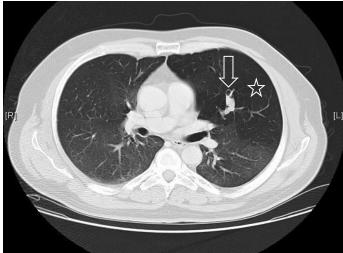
The previous left mid zone nodule is revealed as mucous impaction on computed tomographic scanning (Arrow). There is atresia of the left upper lobe bronchus and the hyperinflation secondary to collateral ventilation is highlighted (Star).
